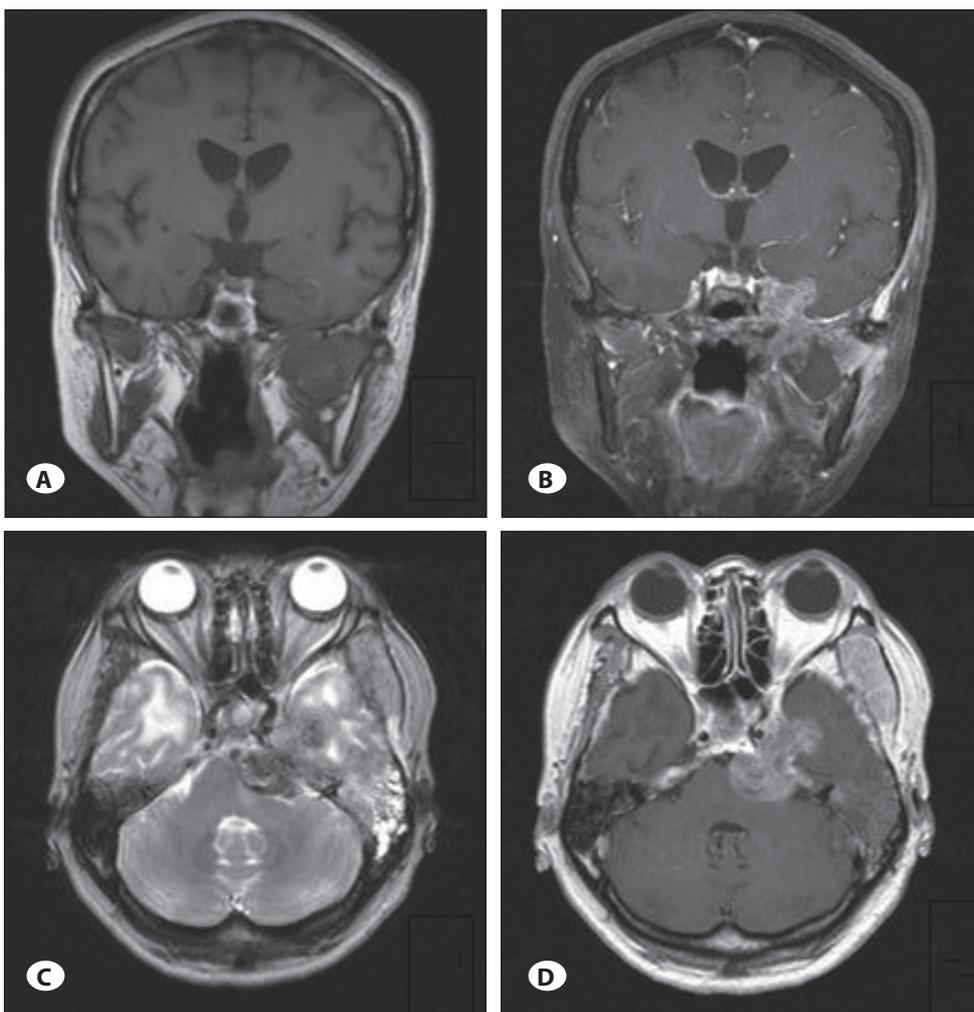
T1W image of MRI showed dumbbell-shaped tumor across the foramen ovale (A). Heterogenous enhancement was demonstrated after injection of gadolinium (B). T2W image showed low signal intensity of the tumor (C). The tumor extended to cerebello-pontine angle. The pons was compressed with enlargement of pre-pontine cistern (D).
